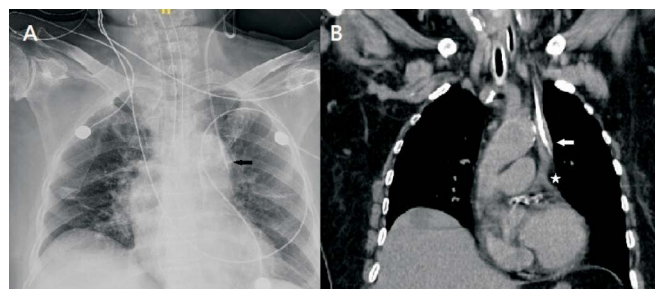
(A) Chest radiograph shows the central venous catheter projecting toward the left paramediastinal position (black arrow). (B) Non-contrast computed tomography of the chest in the coronal view, demonstrates the central venous catheter in the left-sided superior vena cava (white arrow), draining into the coronary sinus of the heart (white asterisk).
